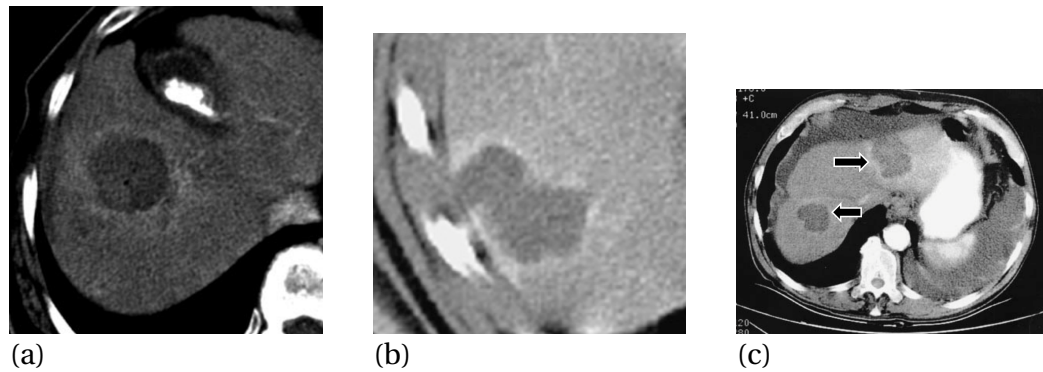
Three examples from the literature of enhanced contrast rims observed in CT images at successively longer times after ablation. (a) 20 mins, Park *et al.* , *RadioGraphics* 28:379-392; (b) 10 days, Vogt *et al.* , *J Nucl Med* 48: 1836-1844; (c) 1 month, arrows show contrast-enhancing tissue representing inflammatory changes that evolve over time on subsequent CT scans; Curley, *Ann Surg Oncol* 10:338-347
